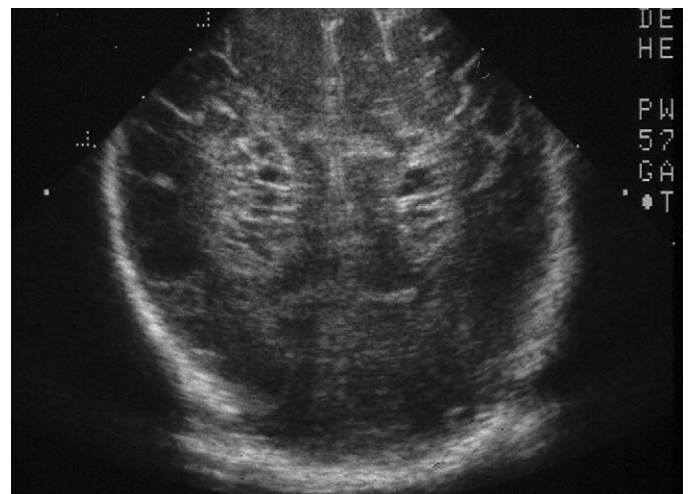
■ Cranial ultrasound scan—coronal posterior view. Note the bilateral cystic areas within the white matter.
